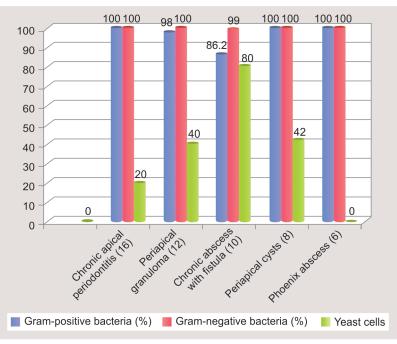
Periapical lesions with the presence of microorganisms in the root canals
